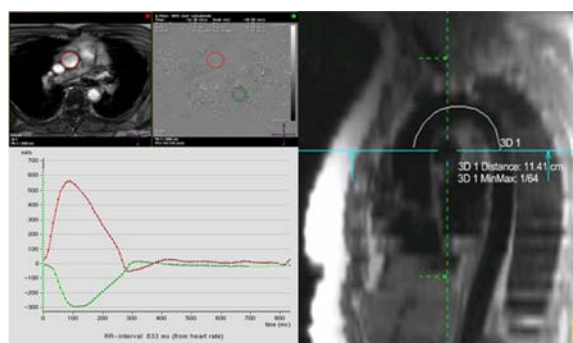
Measurement of time delay and aortic path length between mid ascending and descending aorta. (Left Upper) Velocity-encoded MRI acquired at mid-ascending (dark circles) and mid-descending thoracic aorta (pale circles). (Left Lower) Corresponding measurement of flow at 2 sites (mid-ascending as black line and mid-descending thoracic aorta as dotted line). (Right) Measurement of aortic path length from multiplanar reconstruction
